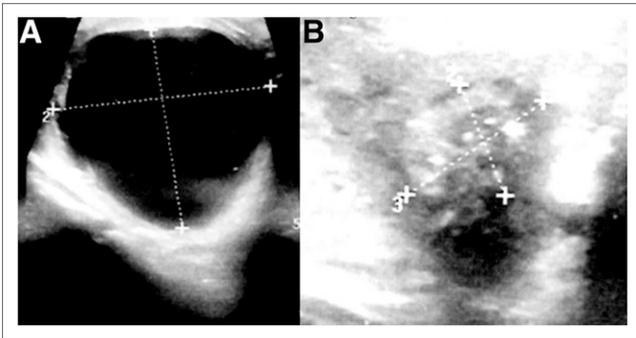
Thyroid ultrasound images. (A) Gross cystic nodule in right lobe of thyroid gland before therapy. Maximum diameter of nodule was $44 \times 49 \times 45$ mm, and volume was nearly 50 cm^3 . (B) Decrease in nodule size and volume after ^{177}Lu -macroaggregated albumin treatment. Albumin particles can be seen in central part of nodule.
